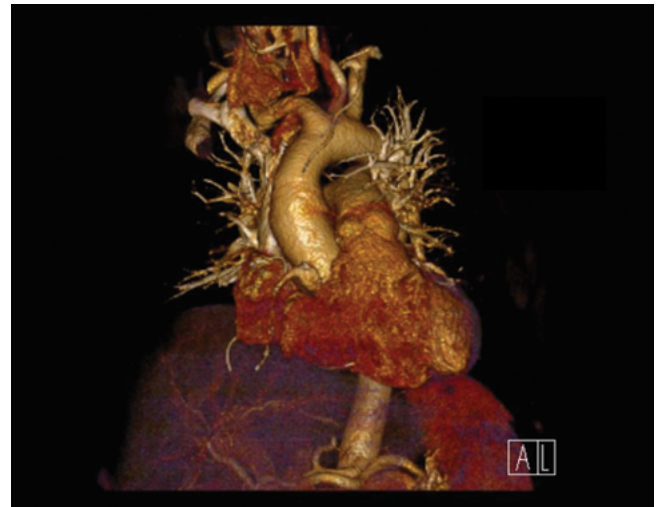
Postoperative computed tomography image obtained 10 years after surgery showing the ascending aorta and right coronary artery.
